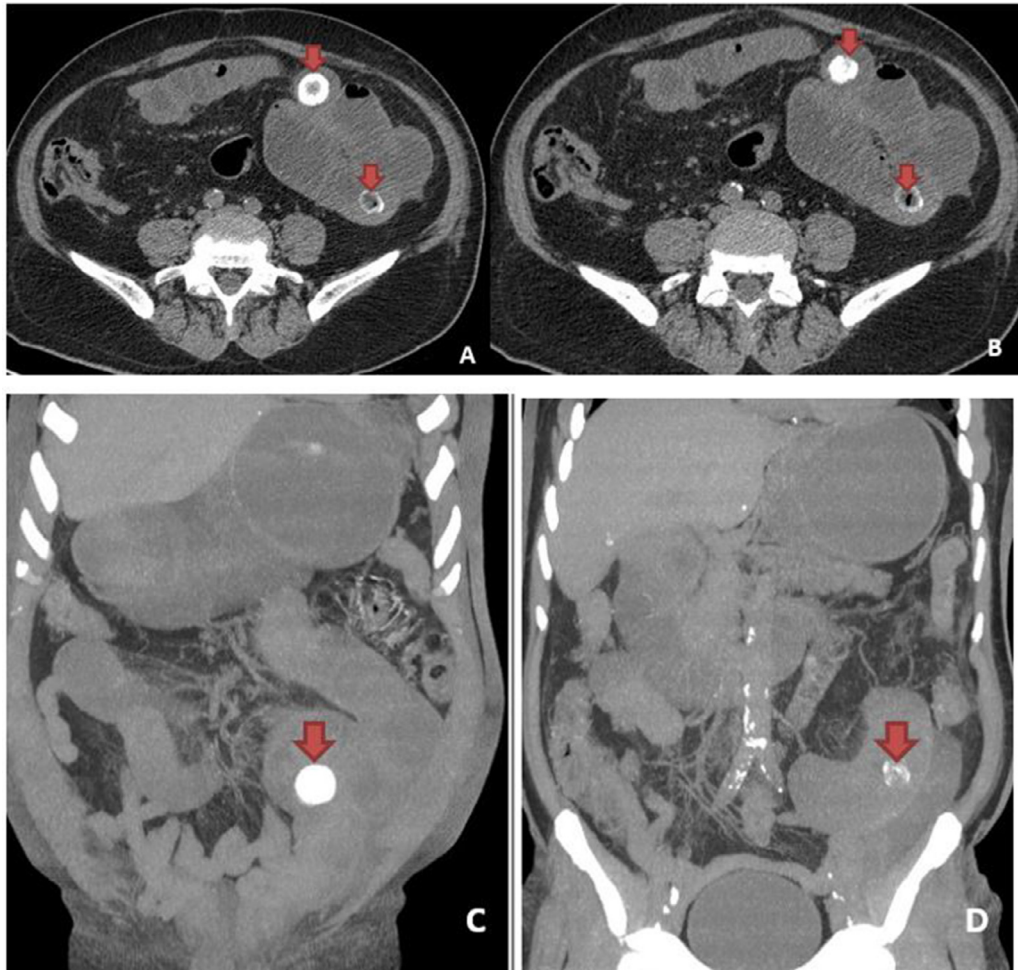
Noncontrast Abdominal CT scan, axial (A, B) and coronal (C, D) plans showing the gall stones (Arrows) obstructing the intestinal lumen. IG
